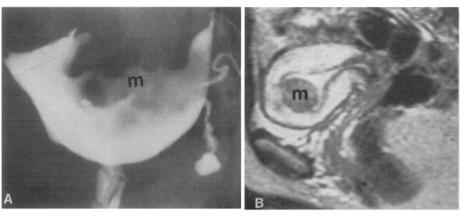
A Large submucous mass (m) distorting and enlarging the uterine cavity. B Sagittal magnetic resonance image of pelvis (TR 2000 ms, TE 80 ms). Hypointense submucous leiomyoma (m) projecting into endometrial cavity.
